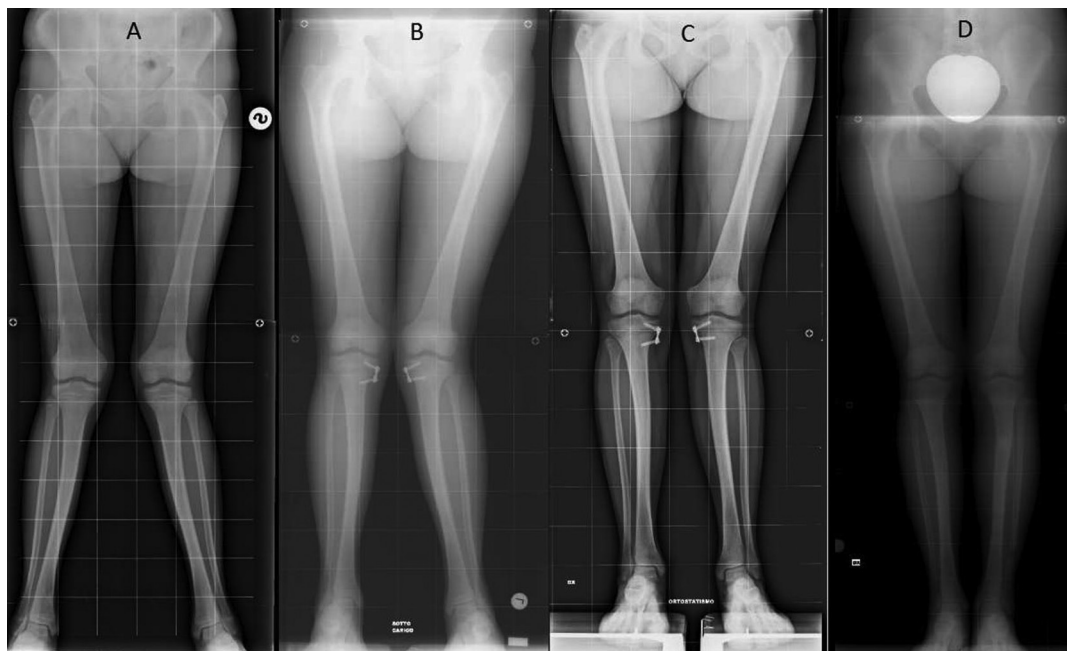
Patient radiograph evaluation: (a) pre-operatively, at 13 years of age; (b, c) periodic follow-up of the patient after surgery; (d) at final follow-up at 16 years of age.
